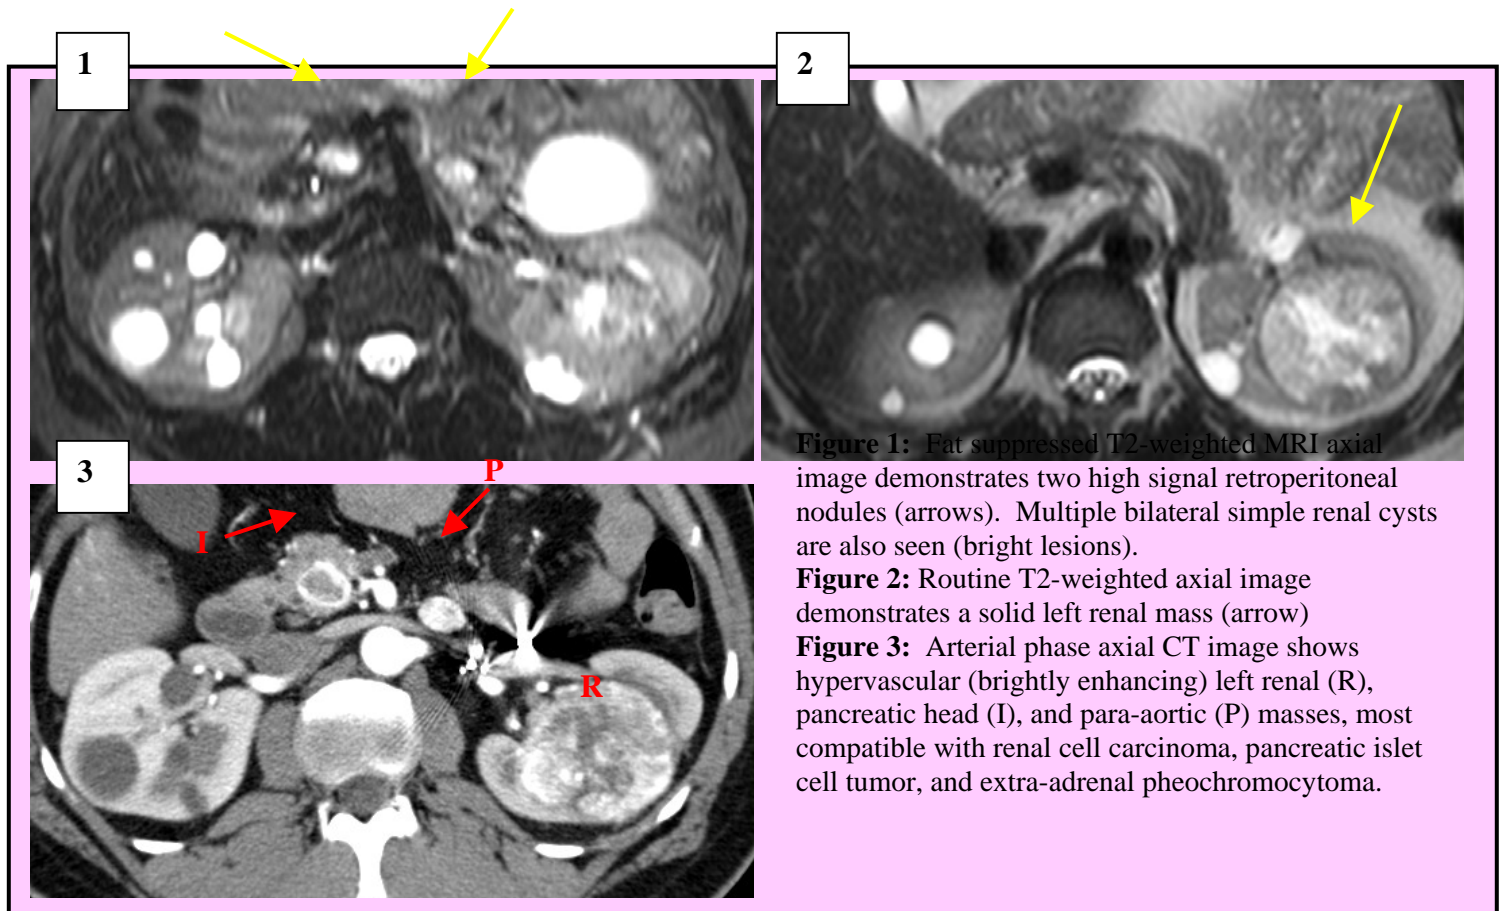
Fat suppressed T2-weighted MRI axial image demonstrates two high signal retroperitoneal nodules (arrows). Multiple bilateral simple renal cysts are also seen (bright lesions).
